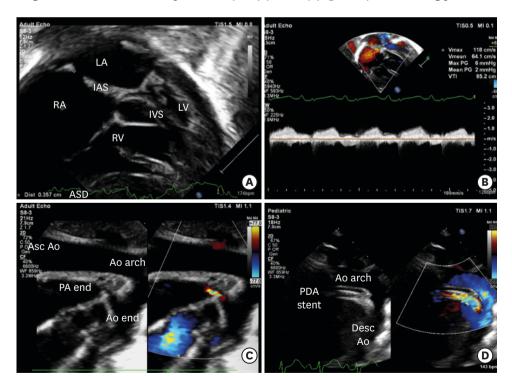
(A) Native atrial septal defect (ASD) measured in the sub-xiphoid coronal view. (B) Continuous wave Doppler across the inter-atrial septum (IAS) showing an inter-atrial mean gradient of 2 mm Hg. (C) Suprasternal long axis view of the aortic arch (Ao arch) at baseline in color compare mode zoomed in to focus on the PDA, showing the large aortic end (Ao end) and the extremely narrow pulmonary end (PA end) (<0.5 mm), suggestive of imminent closure. A measurement obtained during echocardiography and intra-procedural sizing (after balloon dilatation of the narrowed pulmonary end) using a coronary balloon with 2 marker bands agreed on a ductal length of 12 mm. (D) Four days after ductal stenting, a suprasternal long axis view of the aortic arch showed a well-flowing ductal stent. Asc Ao: ascending aorta, Desc Ao: descending aorta, IVS: inter ventricular septum, LA: left atrium, LV: left ventricle, RA: right atrium, RV: right ventricle.
